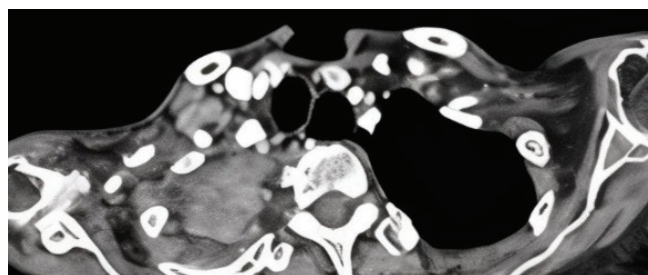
Chest CT image of a patient with a mass in the right lung, who presented to the clinic on the same day for excision of a palpable supraclavicular lymph node, with a diagnosis confirmed after excision.
